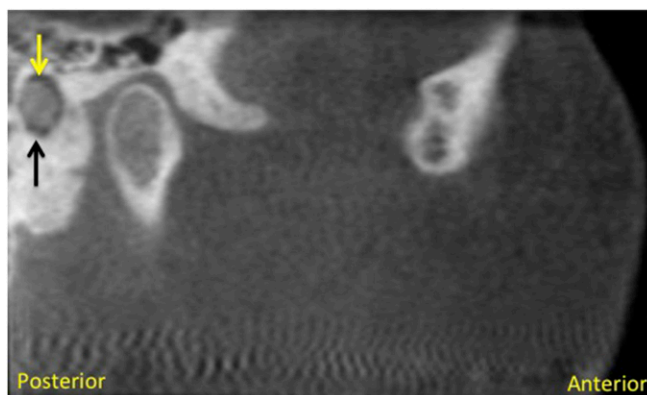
CBCT slice in the sagittal plane showing the foreign body (yellow arrow) in the right external auditory canal (black arrow).
